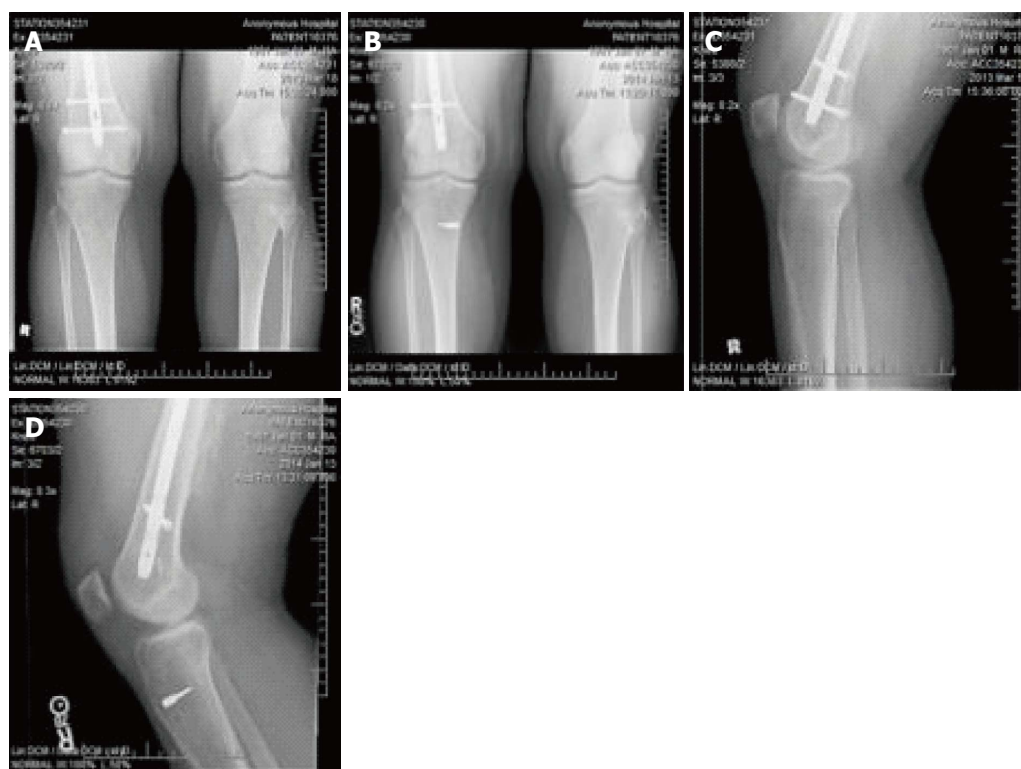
Preoperative and postoperative imaging of distal femoral hardware. Anterior cruciate ligament (ACL) reconstruction required removal of existing distal femoral locking screw located approximately 2 cm superior to the intercondylar notch adjacent to posterior femoral cortex and oriented from posterolateral to anteromedial. A: Preoperative Coronal X-ray; B: Postoperative Coronal X-ray; C: Preoperative Sagittal X-ray; D: Postoperative Sagittal X-ray.
